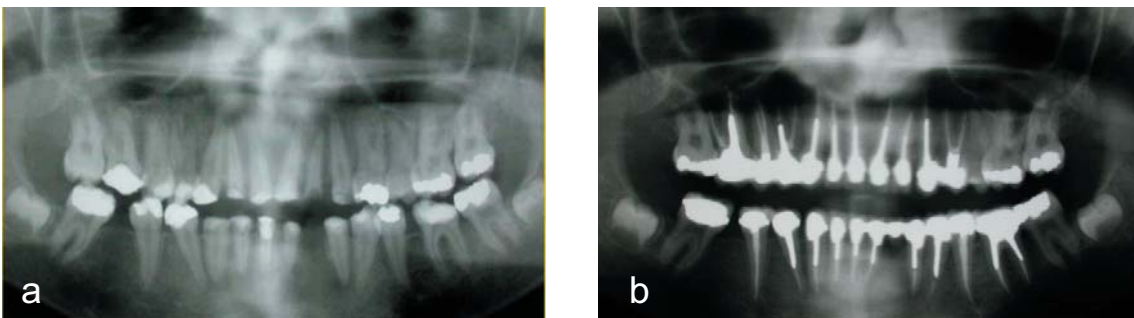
a&b. OPG radiographs before and after treatment.
